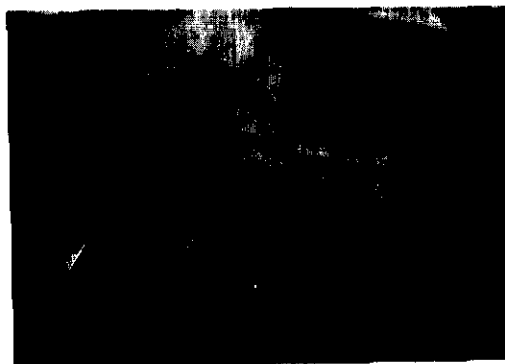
Preoperative panoramic radiograph of right mandible showing an expansile lesion extruding from the lower border of the mandible with periosteal reaction (arrowhead).
